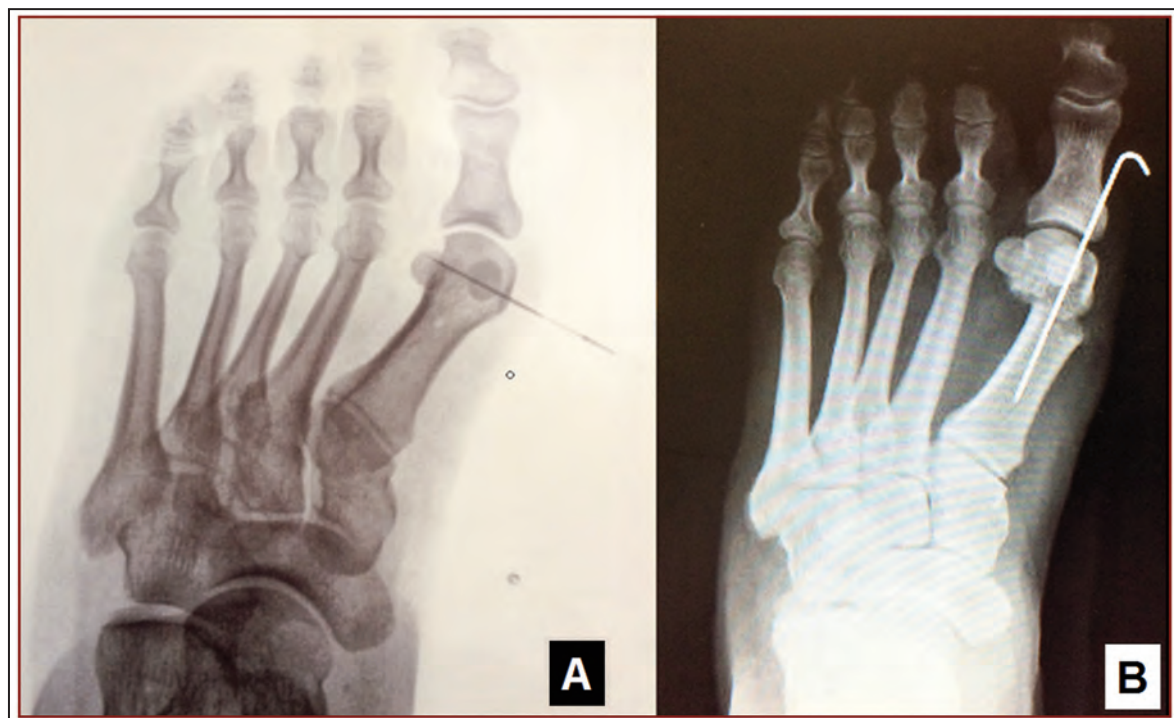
Systemic Foot Surgery with the main Phylogenetic Optimization interventions regarding the Forefoot: A) X-ray of the right foot of a 40 year old worker with Hallux Valgus in painful progression towards the Triangular Forefoot. B) the X-ray control after the minimally invasive percutaneous osteotomy of the I metatarsal neck documents the optimal closure of the metatarsal fan and realignment of the hallux.
